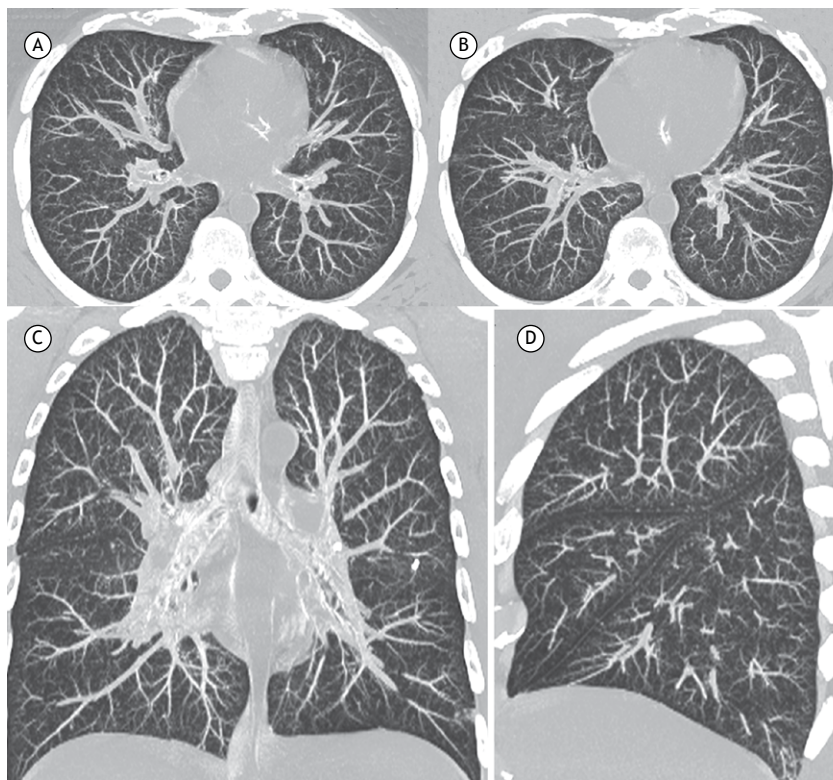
Axial (in A and B), coronal (in C), and sagittal (in D) reformatted CT images in maximum intensity projection show small, randomly distributed nodules. Also, note small nodules along the pulmonary fissures in C and D.
